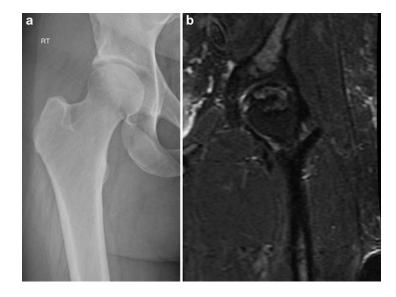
Imaging osteonecrosis of the femoral head. (a) AP radiograph of a patient with osteonecrosis and hip pain. The radiographs do not show the lesion. (b) T2-weighted MRI scan shows the lesion within the weight-bearing region of the femoral head
